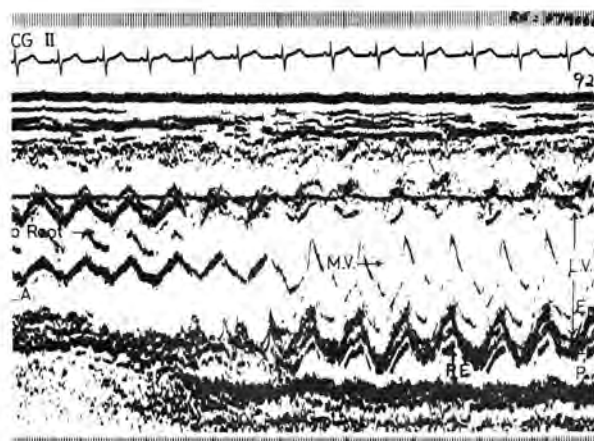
Echocardiogram showing large anterior and posterior pericardial effusion.
